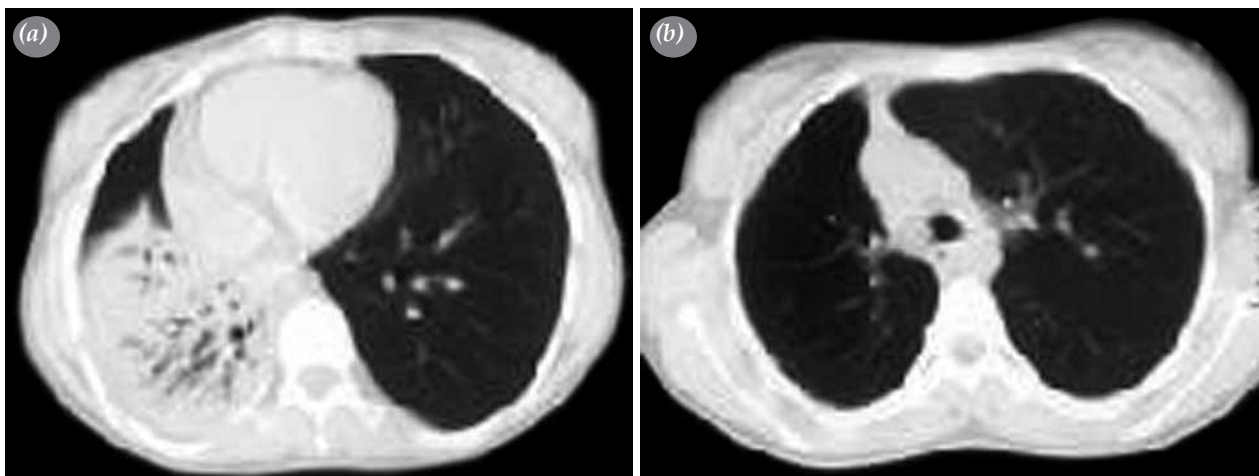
Contrast-enhanced axial computed tomography image displayed in the soft-tissue window setting (a) demonstrates heterogenous consolidation in the right lower zone and (b) an endobronchial mass lesion in the right main bronchus entrance.
